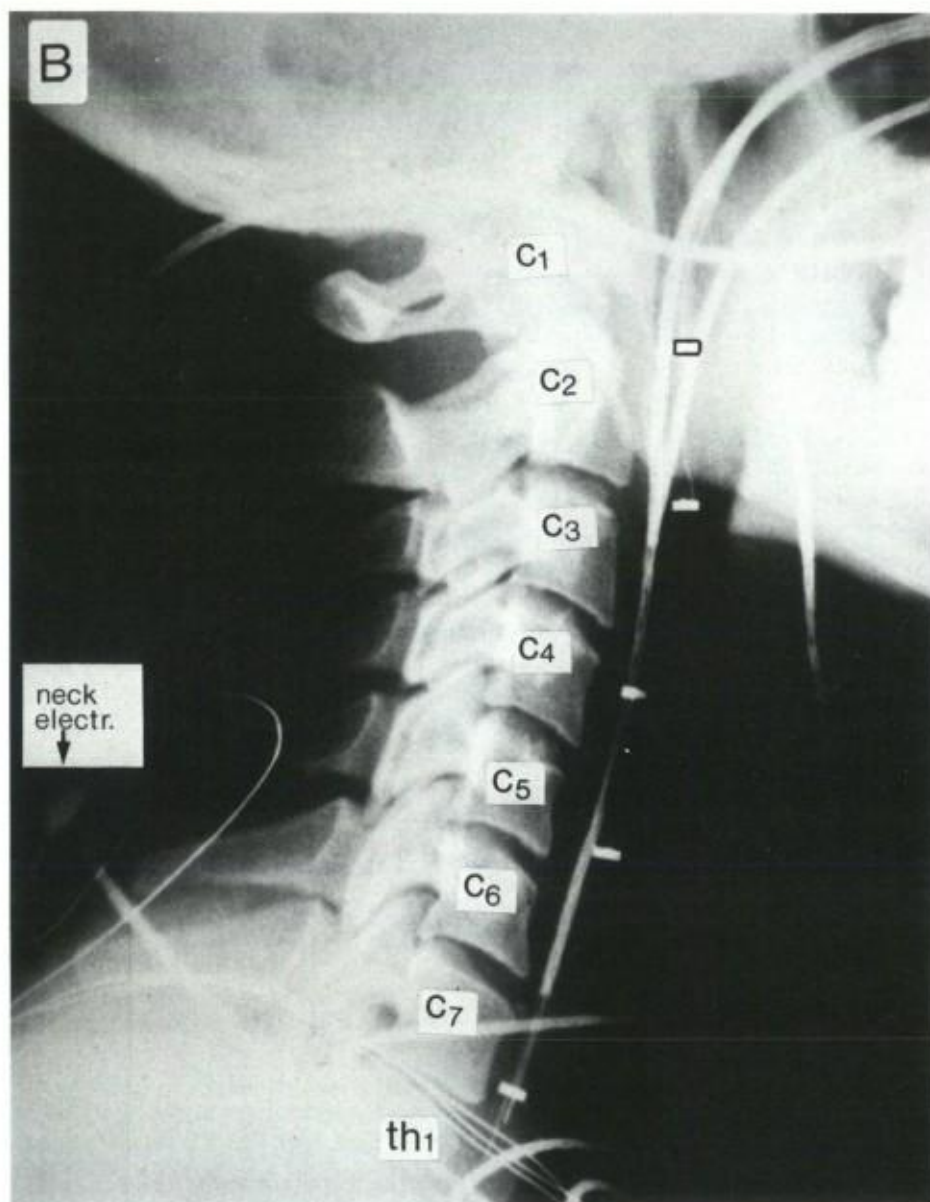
A: photograph of the probe used for oesophageal recording. The two (dark) circular metal contacts on the perspex terminal are separated by 23 mm. B: lateral X-ray of the cervical spine with 6 oesophageal electrodes (3 probes each with a pair of metal strips) in place in front of the vertebrae which are labelled. A Beckman cup electrode can be seen over the spinous process of vertebra C6.
